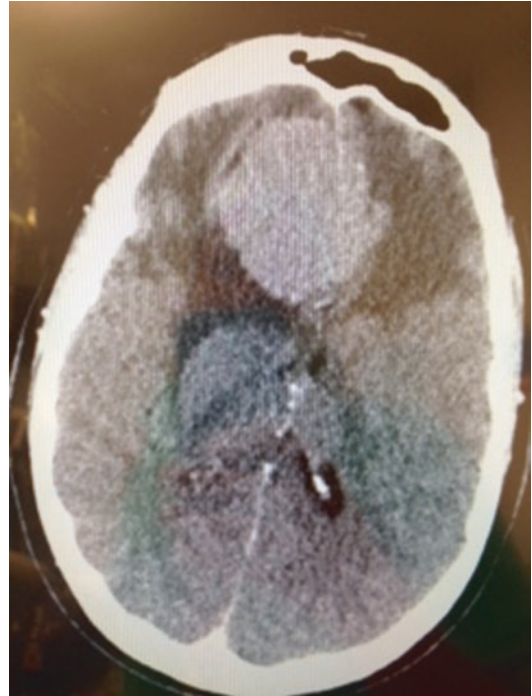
Computed tomography (CT) of a 37-year-old, 18-week pregnant patient admitted for sudden blindness. Unenhanced axial CT scan images of the head show a midline parasagittal meningioma of the cerebral falx
